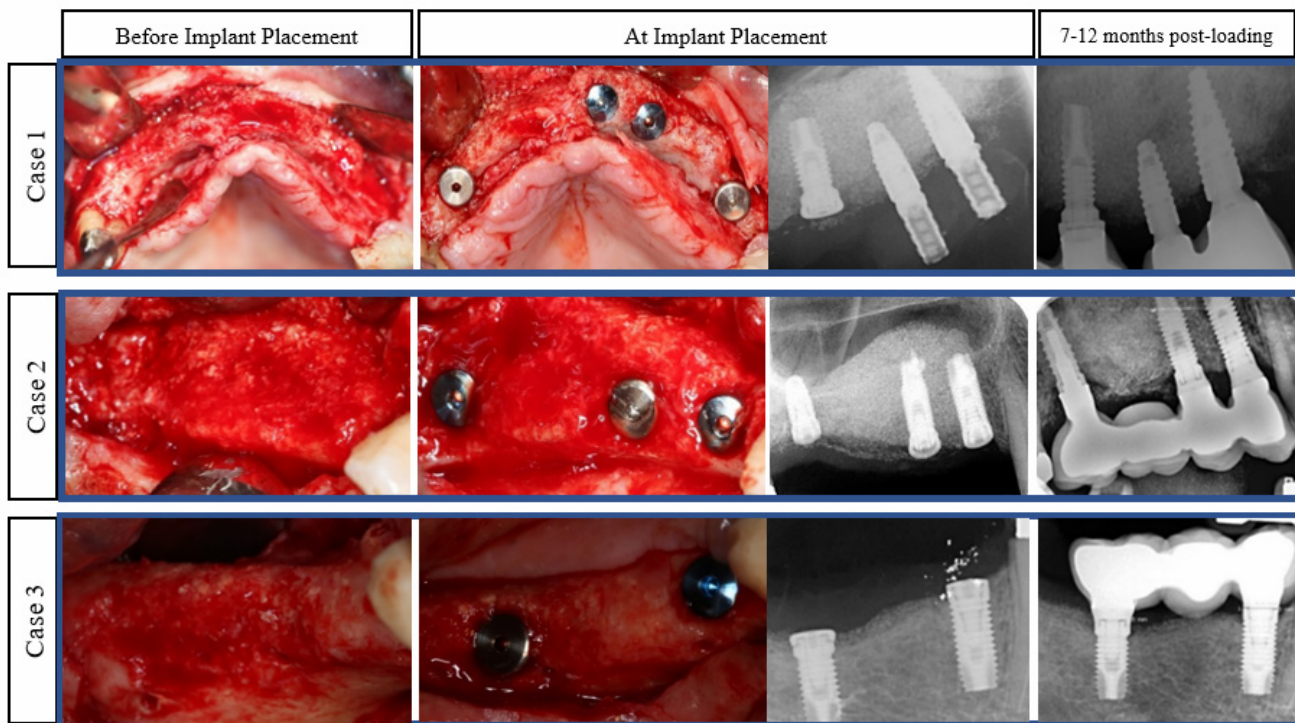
Clinical pictures (before and during implant placement) and radiographic x-rays (at implant placement and 7 to 12 months after crown delivery) of the clinical cases. Note the small bone remodeling around the placed implants after 7 to 12 months of fixed
